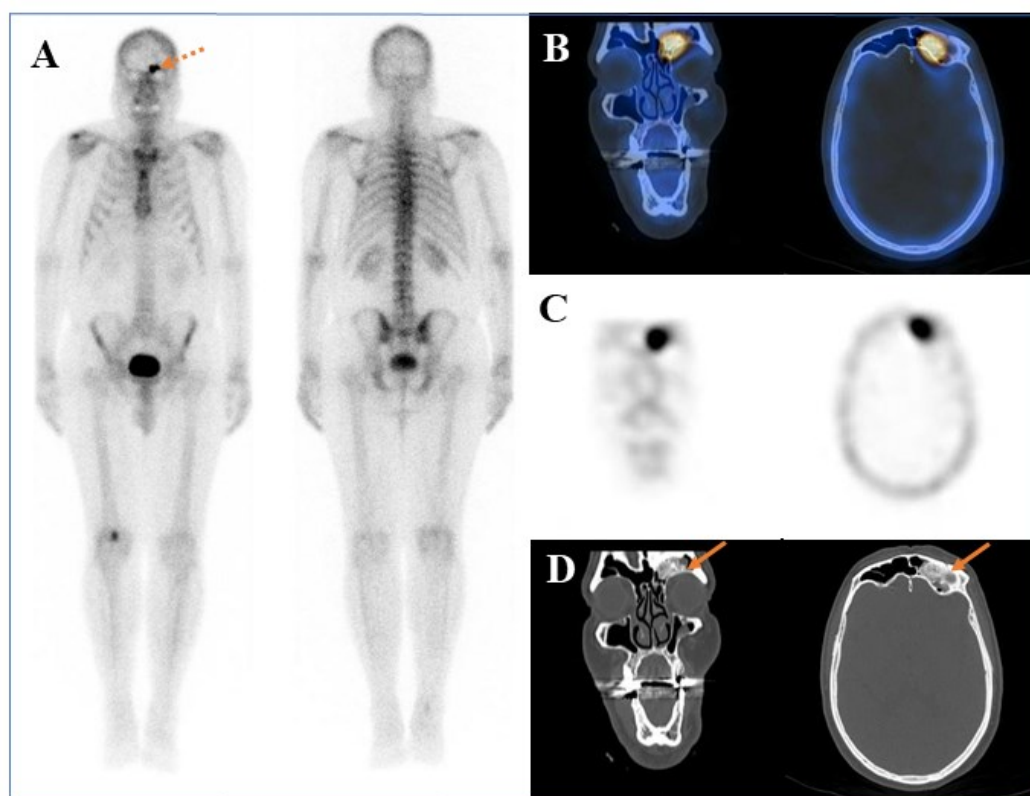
Incidental focal tracer uptake in the left frontal bone on planar bone scan (A, dotted arrow) was confirmed by subsequent SPECT/CT and SPECT imaging (B, C) and identified as a well-defined osteoma in the left frontal sinus on CT (D, arrows)
